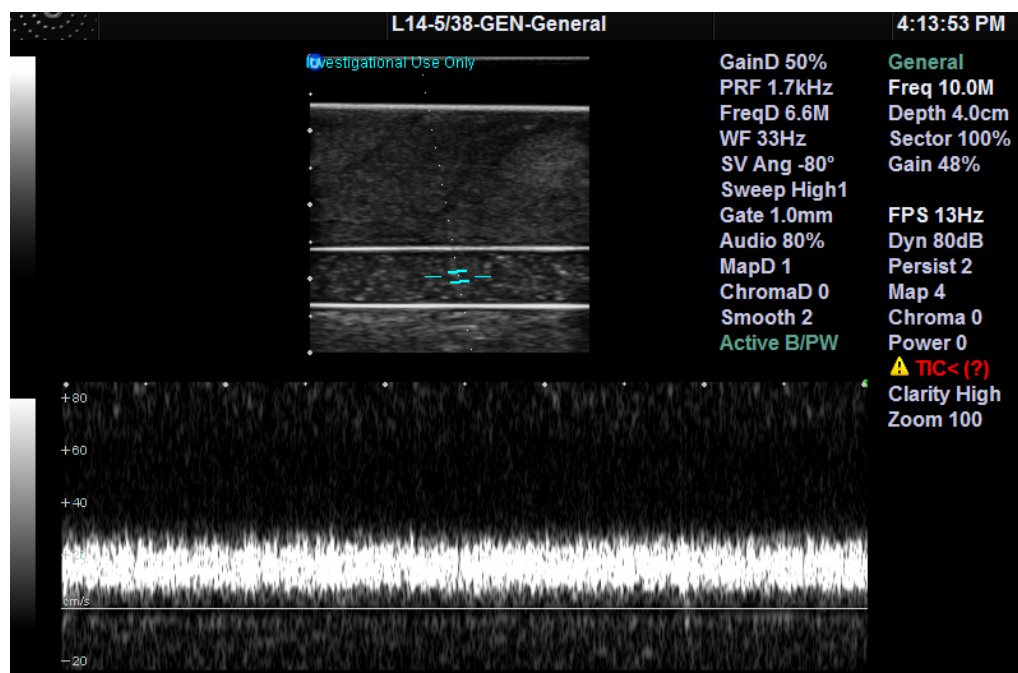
Duplex display of the B-mode image and the Doppler spectral mode showing the CCA vessel and the velocity spectrogram from a sample volume placed at the center of the vessel, as indicated by the cursor in the B-mode image.
